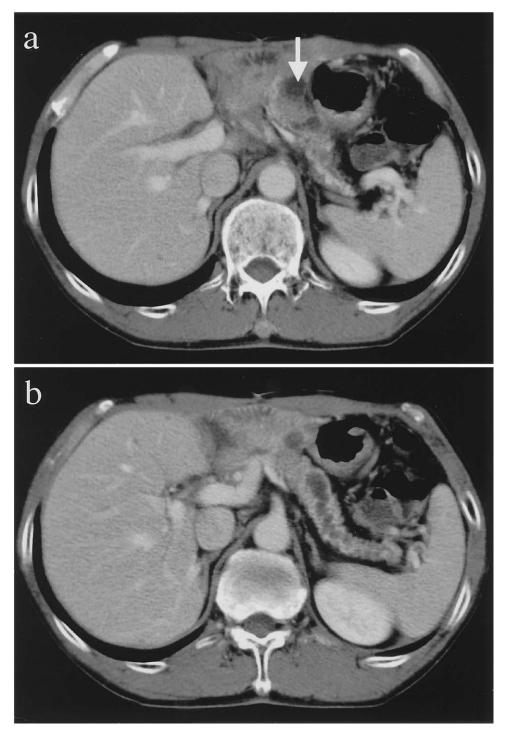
Abdominal computed tomography. (a) The tumor (*arrow*), which protruded into the main pancreatic duct, was observed near the anastomotic site of the pancreaticojejunostomy. (b) The main pancreatic duct of the remnant pancreas was dilated.
